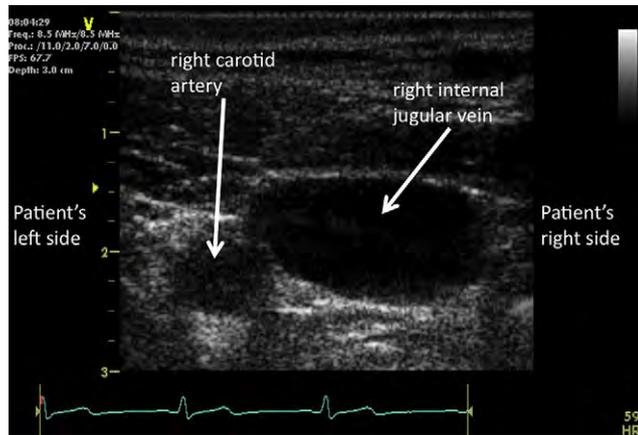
Right neck central vein cannulation. The ultrasound probe is held so that each side of the screen displays ipsilateral structures. With the probe mark placed on the upper left corner of the image, the displayed structures will move in the same direction with the probe.
